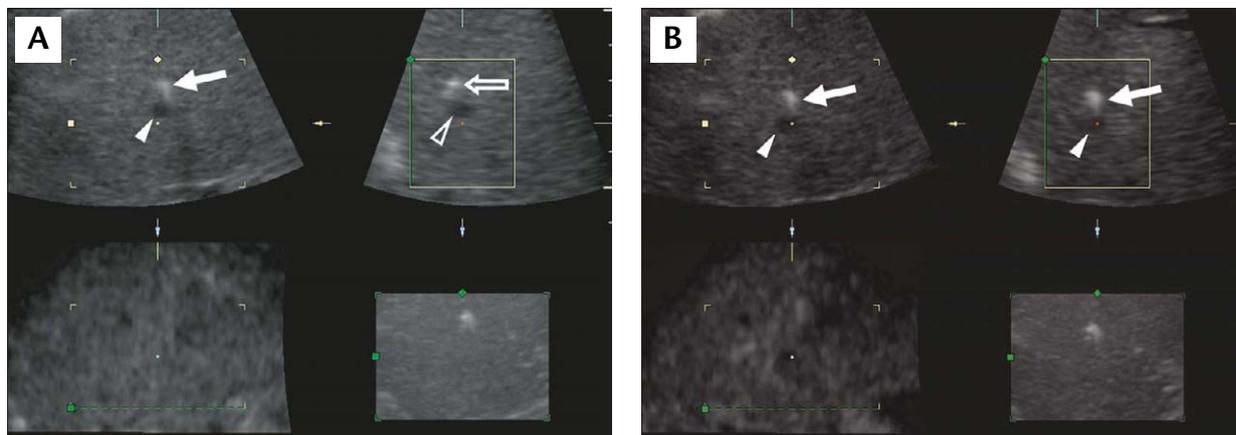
Four-dimensional ultrasound (US) during radiofrequency ablation for a small metastatic nodule. The top left image is transverse; the top right image is sagittal; and the bottom left image is coronal planar. The three displayed imaging planes are perpendicular to each other. The bottom right image is a three-dimensional volume-rendered image obtained by mixture of the transparent maximal and surface modes. (A) Even though the needle (arrow) seems to advance toward the center of small low echoic nodule (arrowhead) in transverse image (top left), sagittal US image (top right) shows that the needle (open arrow) is located slightly cranial to the nodule (open arrowhead). (B) After readjusting the needle slightly caudally, both transverse (top left) and sagittal (top right) US images show the needle (arrow) targeting the center of the nodule (arrowhead).
